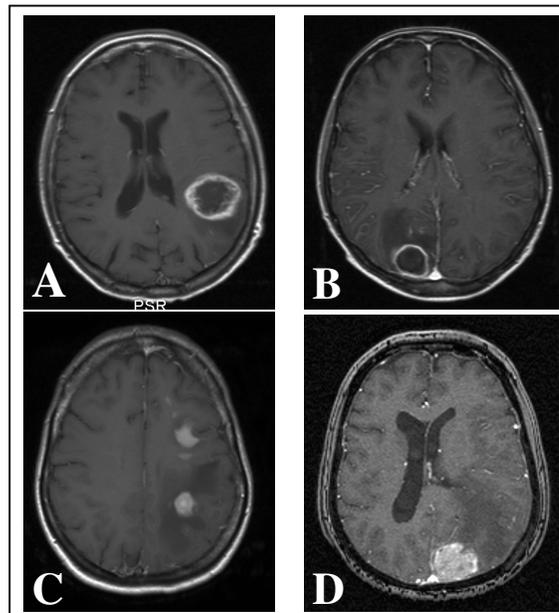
Conventional T1-weighted MRI scans of A. Glioblastoma multiforme; B. Abscess; C. Primary CNS lymphoma; D. Metastasis from breast cancer.
